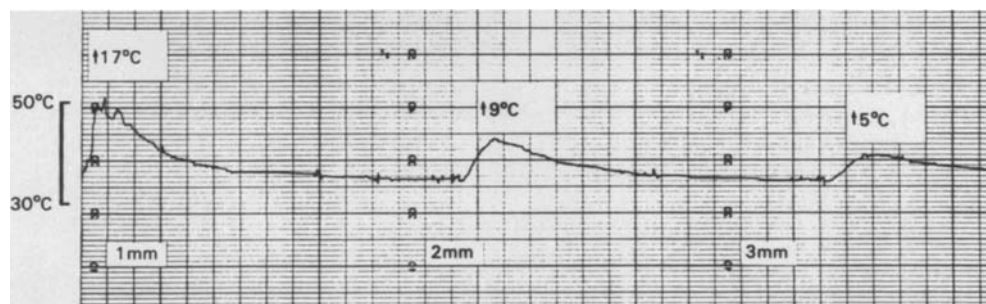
Tissue heating effects of ultrasonic scalpel. Recording of temperature rise at 1, 2 and 3 mm from the point of application of the tip of the ultrasonic scalpel in the minipig bladder mucosa
